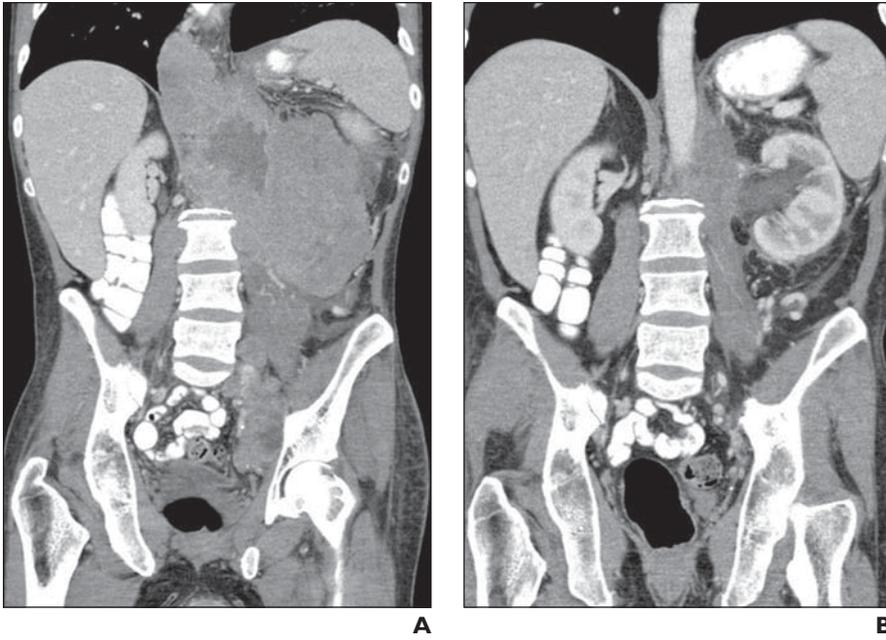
38-year-old man with favorable subset who presented with midline poorly differentiated carcinoma. A, Coronal image from initial contrast-enhanced CT shows large heterogeneous retroperitoneal mass with internal necrotic component. Scrotal ultrasound did not reveal any abnormality. Pathology revealed poorly differentiated carcinoma. Serum β -HCG and α -fetoprotein were elevated. On basis of clinicopathologic and imaging findings, patient was treated for extragonadal germ cell tumor. B, Coronal contrast-enhanced CT after three cycles of platinum-based chemotherapy shows mass has significantly decreased in size.
